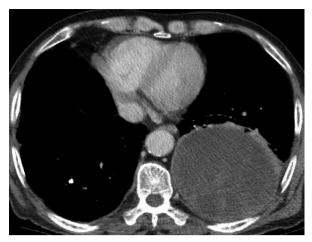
Chest CT showed a 9.7×8.7 cm soft tissue mass in the left lower lung, and left pleural effusion.
